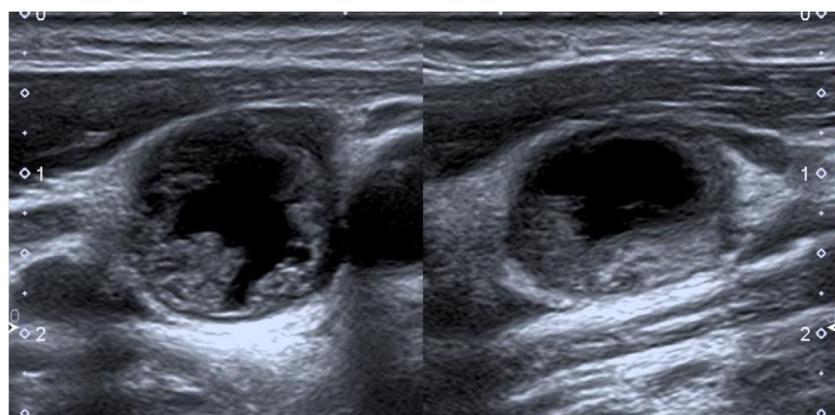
Ultrasound aspect of cystic cervical metastasis at the sector II/III junction from an HPV+ squamous cell carcinoma: longitudinal (1a) and transverse sections (1b).
